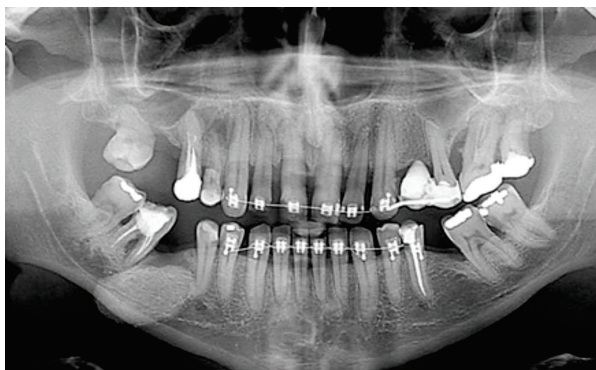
Panoramic Radiography. It is possible to observe radiopaque image, well delimited, with about 3 cm in its largest diameter.
